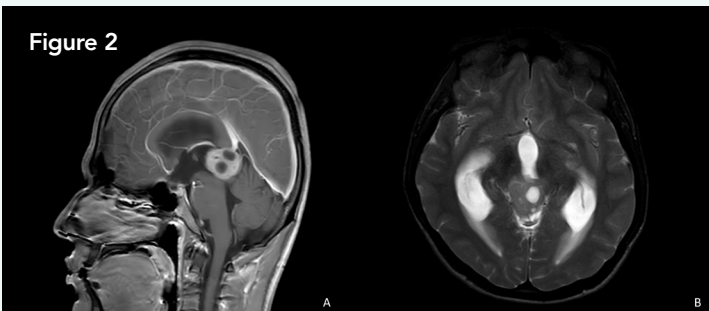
MRI of the brain T1 with contrast sagittal section demonstrates heterogeneously enhancing tumor in the pineal region (A). Axial T2 MRI demonstrates pineal region mass with hydrocephalus (B).
